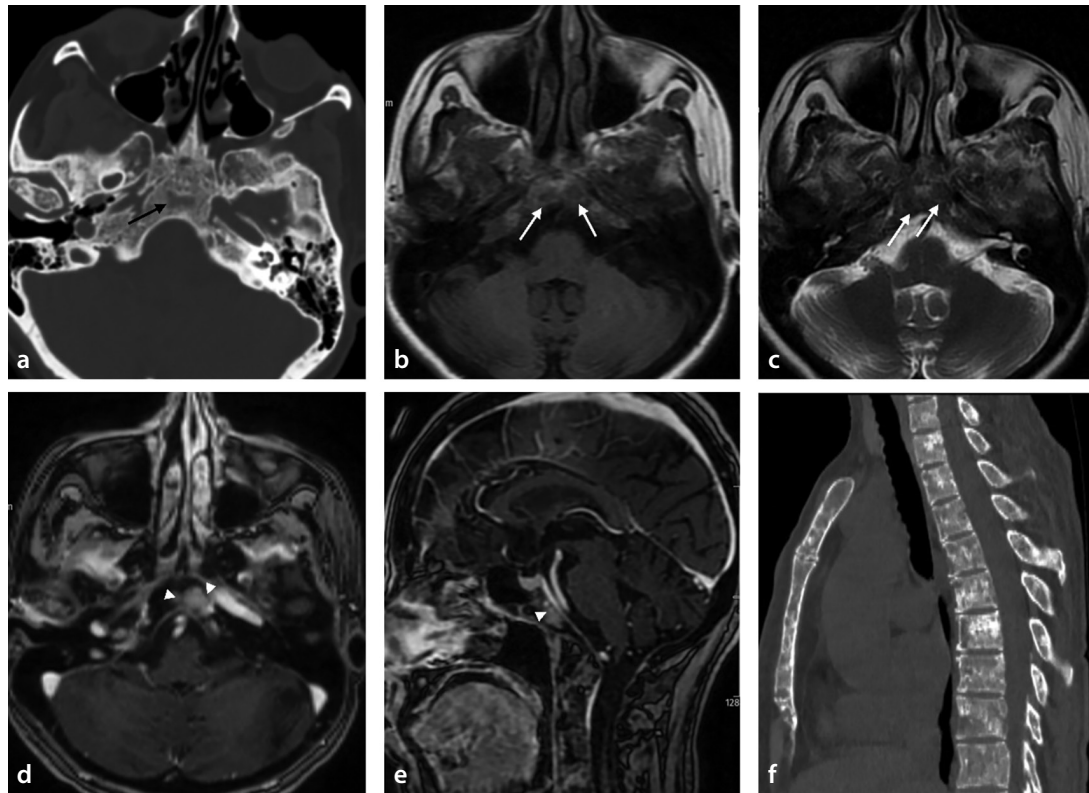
Images of a 60-year-old female patient diagnosed with breast cancer revealing clivus metastasis. Computed tomography (CT) scan (a) demonstrates a lytic lesion (black arrow). Axial T1-weighted (T1W) magnetic resonance imaging (MRI) (b) and T2-weighted MRI (c) reveal hypointense lesions (white arrows). Axial (d) and sagittal (e) post-contrast T1W images demonstrate homogeneously enhancing lesions (arrowhead). Sagittal CT image (f) revealing mixed lytic and sclerotic lesions consistent with mixed-type bone metastasis.
